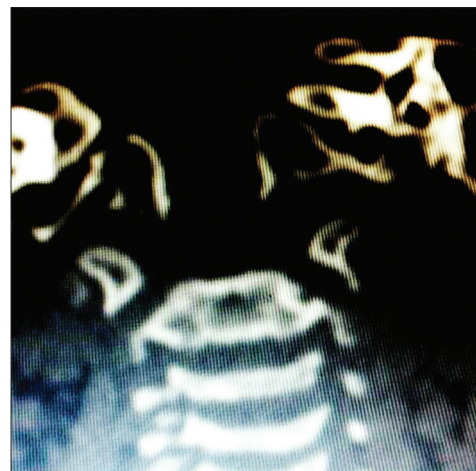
CT of the child with nonossification of the dens
